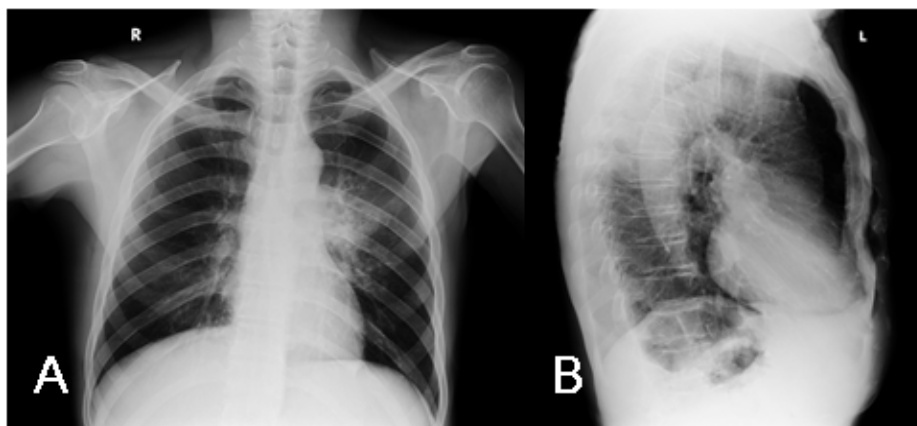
A: chest X-ray (PA). B: left lateral chest X-ray. The left hilar region projection shows a poorly defined radiopaque image with spiculated contours causing hilar thickening, measuring approximately 27x43 mm and obliterating the vascular structures at that level
